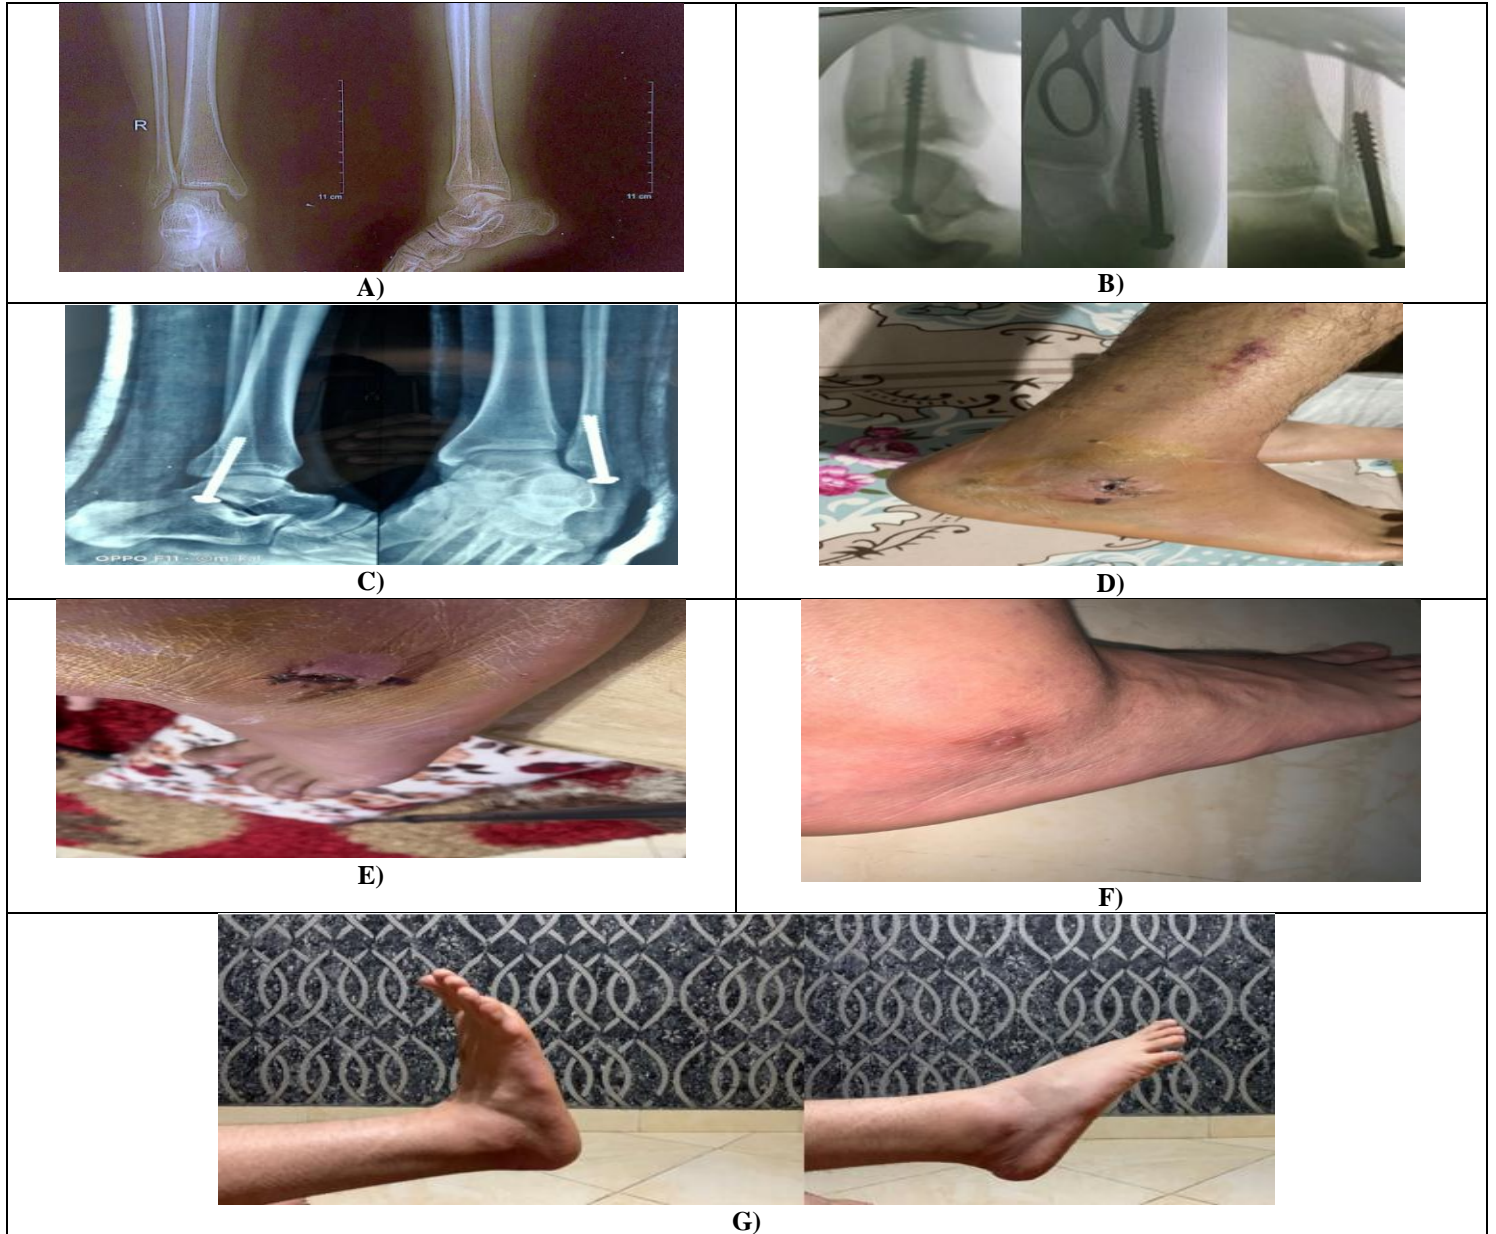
(A) Right ankle preoperative x-ray, (B) Imaging during surgery C) X-ray taken four weeks after surgery; D) pic taken two weeks after surgery revealing the skin entry incision; E) photo taken four weeks after surgery showing the removal of the flap; F) photo taken six weeks after surgery showing the healing of the skin entry wound; and G) photo taken eight weeks after surgery showing the ankle joint's nearly full range of motion.
